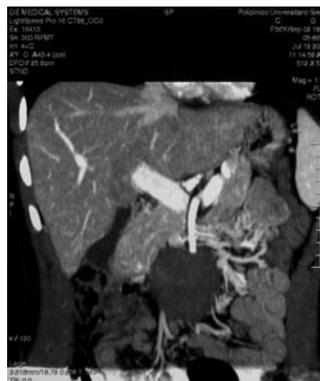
Coronal view of computed tomography scan shows a mesenteric desmoid tumor.
